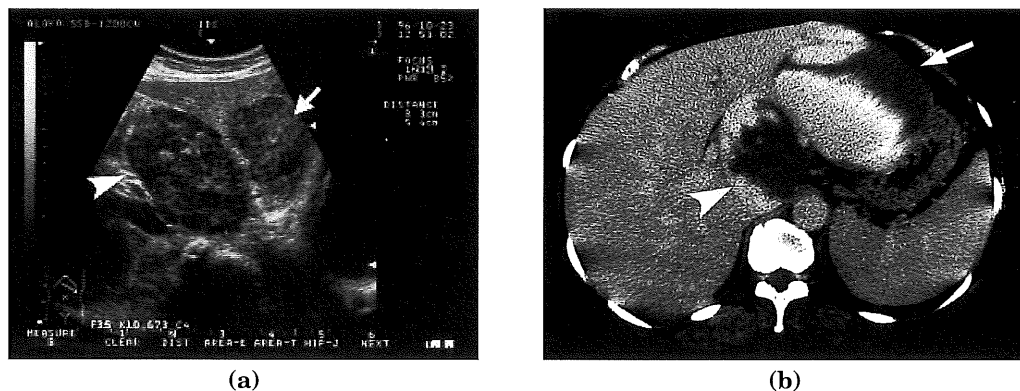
(a) Preoperative abdominal ultrasonogram of case 7, showing cavernous hemangiomas located in the lateral segment (arrow) and caudate lobe (arrowhead) of the liver. The echo patterns were heterogeneous. (b) CT scan after intravenous injection of contrast material, showing peripheral enhancement of the lesions (arrow and arrowhead).
